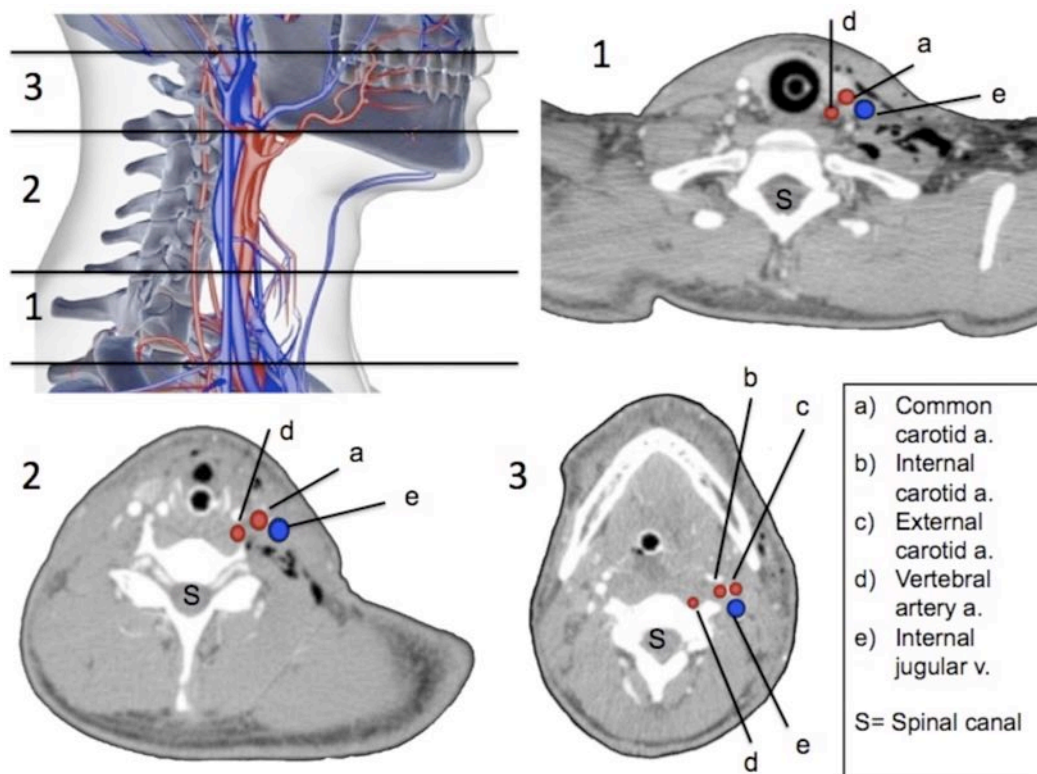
Pictorial demonstration of the three zones of the neck using axial CT scans at the vertical midpoint of each zone (for clarity the spinal cord is not shown on the sagittal view).
